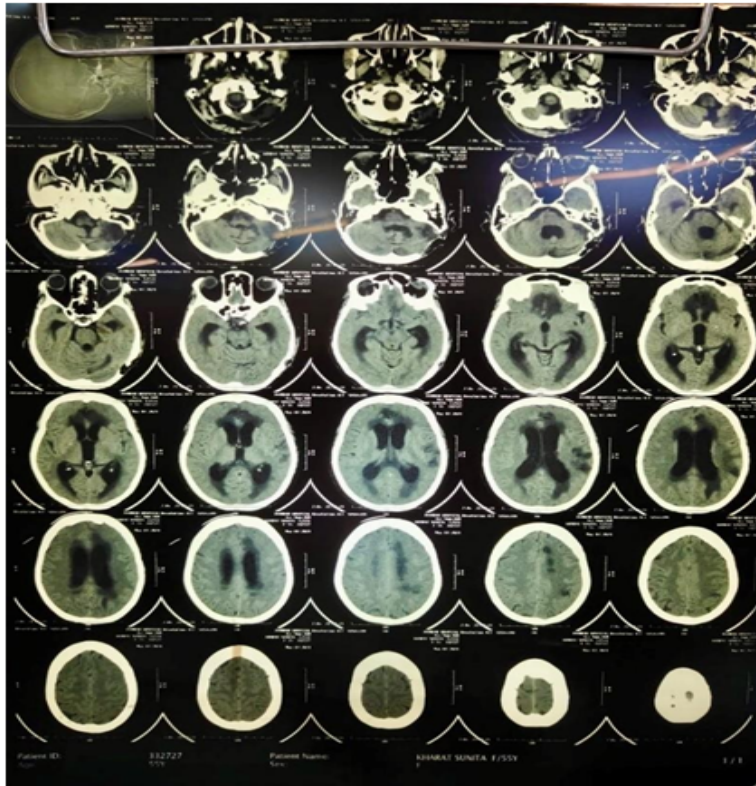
CT head (contrast) scan was done to reveal a hypodensity in the bilateral frontal lobes suggestive of ischemia of bilateral frontal lobes.
